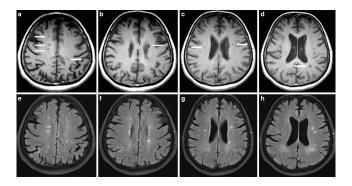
Examples of black holes indicated by white arrows in four PPMS patients. Top row: Axial T1-weighted spin-echo images. Bottom row: Axial fluid attenuated inversion recovery (FLAIR) images with corresponding hyperintense lesions in the same locations.
